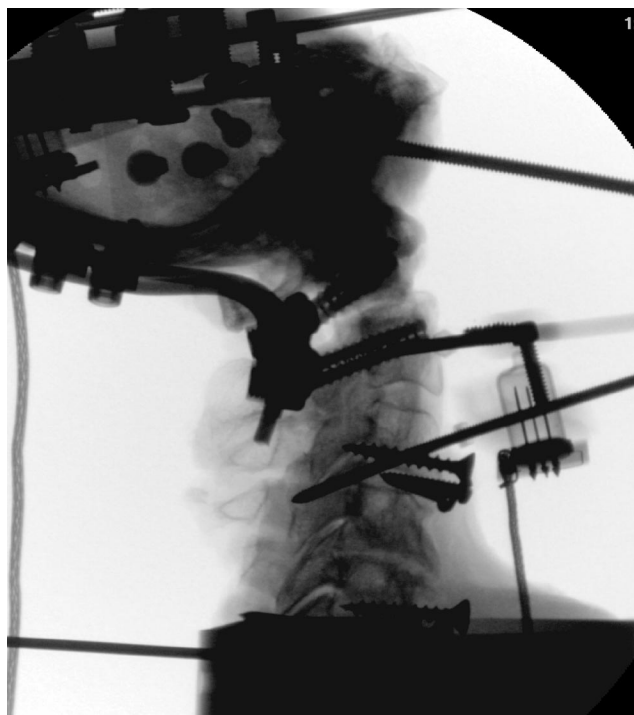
X-ray showing pedicle screw technique using C2 pedicle screws.
